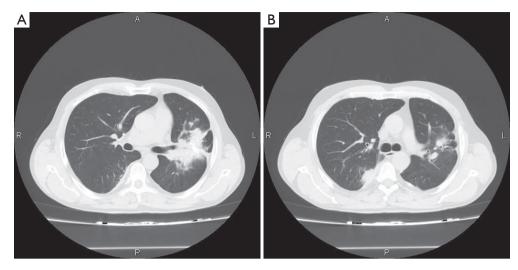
Chest CT shows an irregular infiltration of 7 cm \times 5 cm in the left lung. An infiltration of 4 cm \times 2 cm can also be seen in the right lung near the vertebral column.
